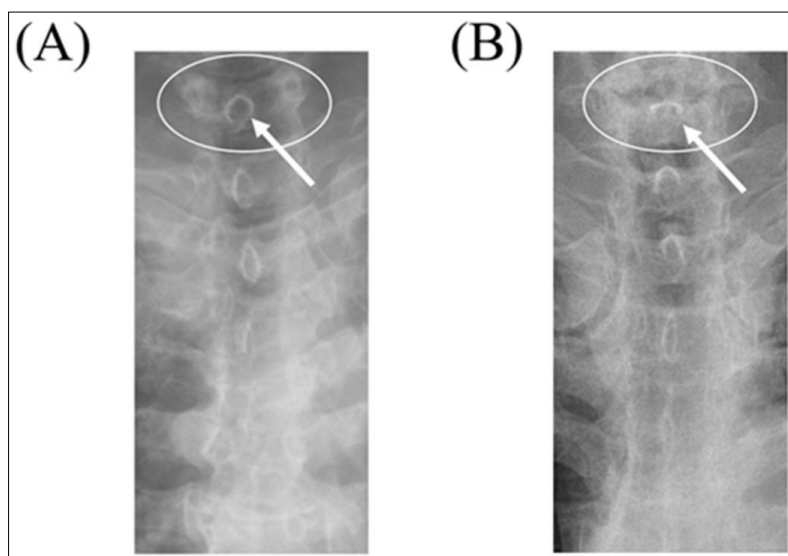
Chest X-ray view of the tracheal region. (A) A chest PA radiograph obtained 8 years earlier and (B) a preoperative chest PA radiograph. Comparison of the two images reveals subtle differences in the shadow of the tracheal lumen in the neck region (arrows), at the level of the sixth cervical vertebra (C6). Additional radiologic findings include mild cardiomegaly, right pleural thickening, and multiple old rib fractures
